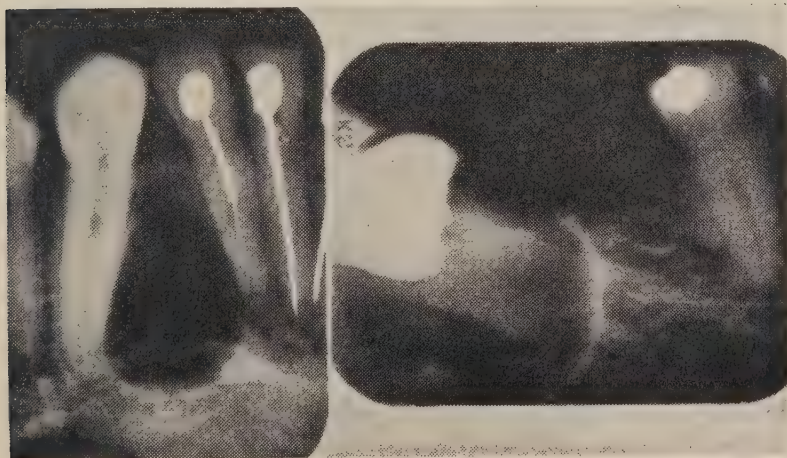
Periapical radiographs showing the same areas as in Figure 5.
